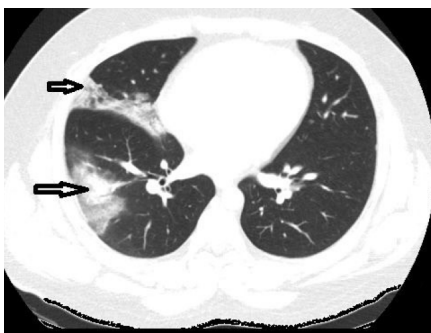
Thirty-two-year-old male. Initial dual-energy computed tomography image. Consolidations (arrows) are present.
